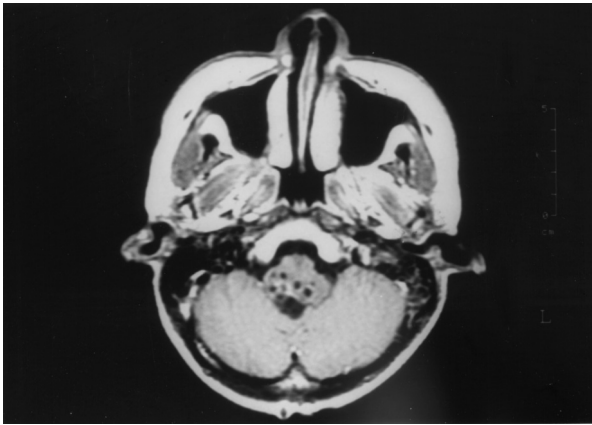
Axial T1-weighted image shows a solid tumor with a cystic component at the pons.
